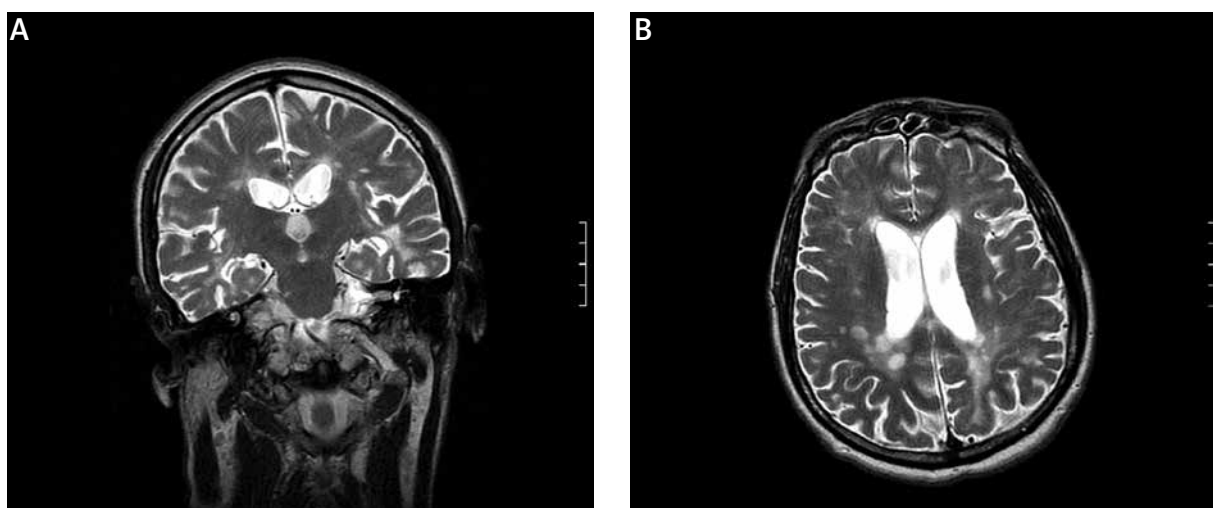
Case 1. A) Coronal and B) axial T2 MR images show multiple focal periventricular/subcortical hyperintense lesions compatible with demyelinating plaques.
